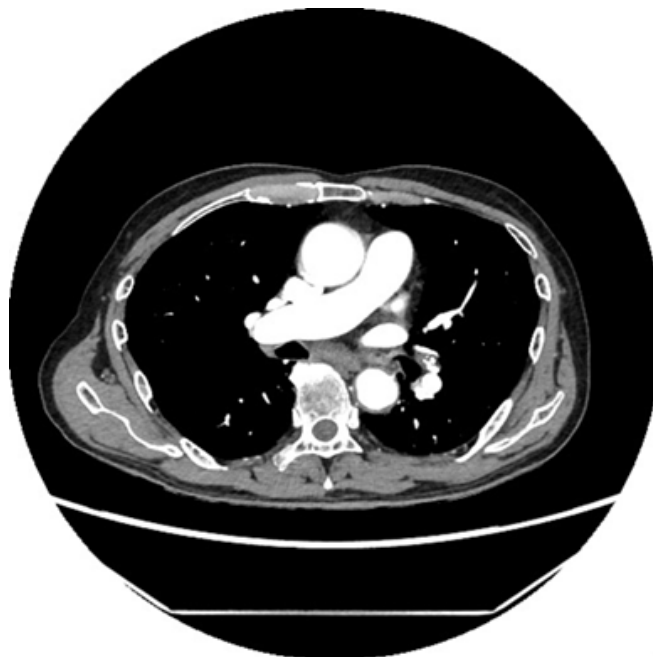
Postoperative Follow-up CT Scan at 12 Months. There is no evidence of metastatic spread to the mediastinum or other sites in the images of the resected region.
